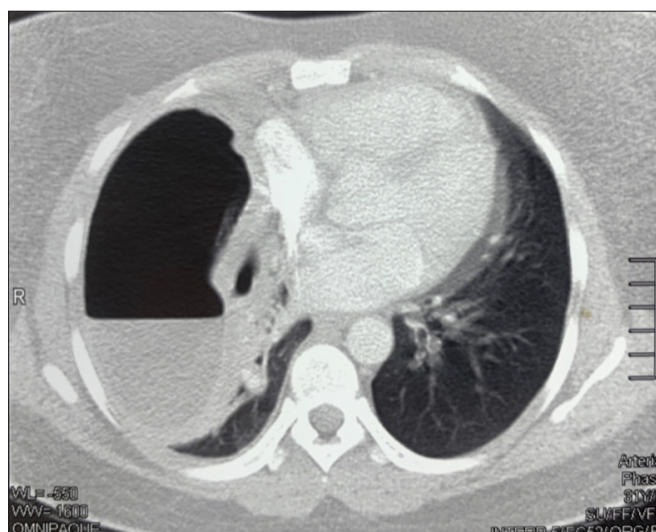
Chest computed tomography (coronal view) showing large lung abscess with dependent air-fluid level.
